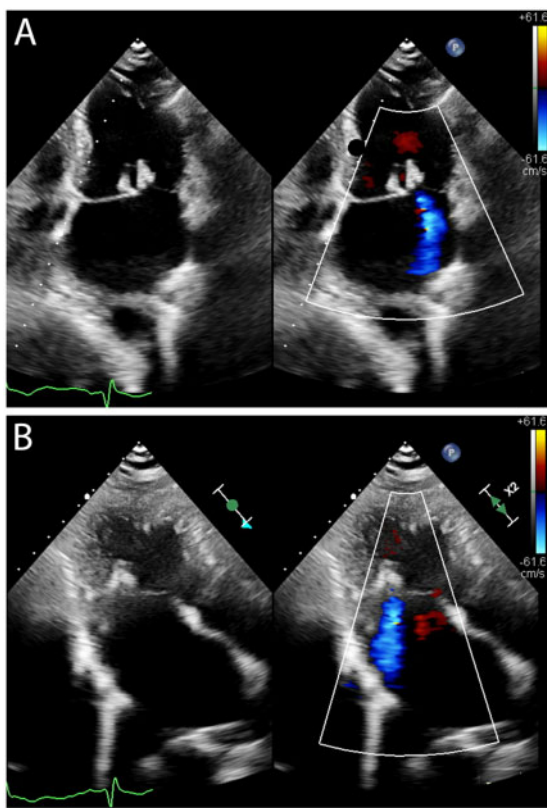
(A and B) Transthoracic echocardiogram images showing stable clips with mild mitral regurgitation 1 month after MitraClip implantation.
